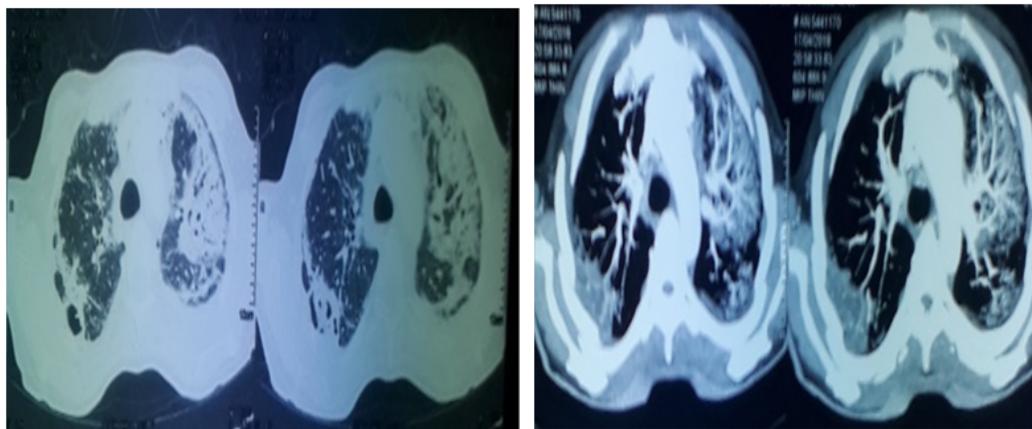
Thoracic CT was objective of peripheral bilateral parenchymal condensation foci.
